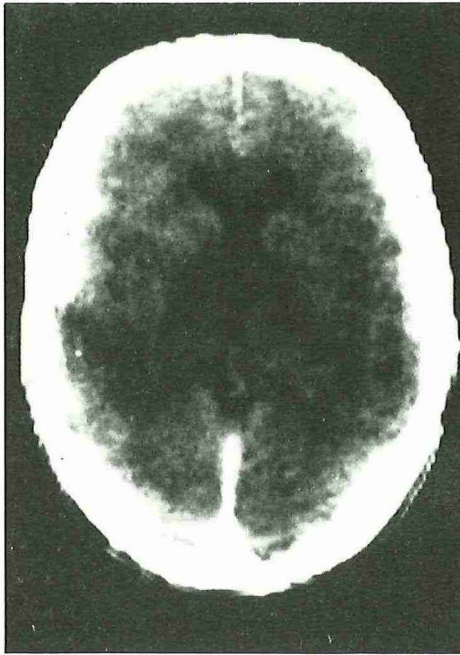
Normal CT scan after radiotherapy (patient no. 1)
